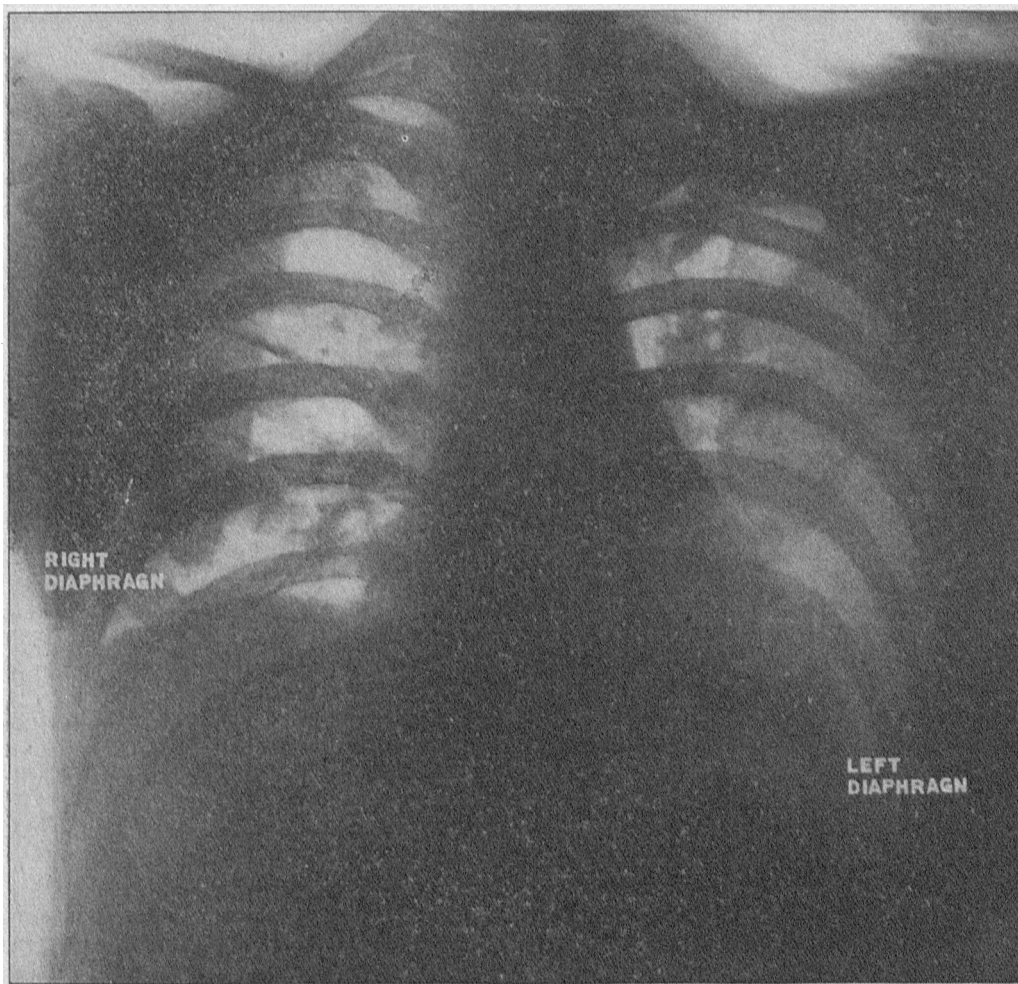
X-ray in supine position of CASE 3. Note diaphragm high and smoothly rounded on right. Gas bubble not visible in this position. (X-ray with portable machine by Dr. Frank Wheatley.)
